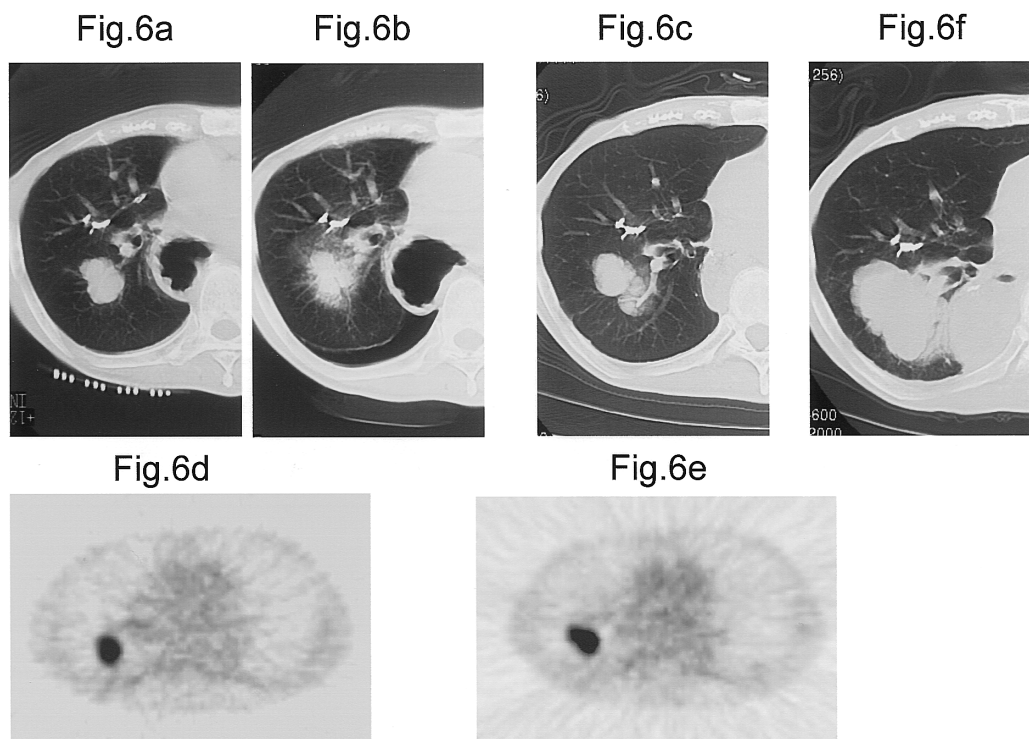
Transverse CT and PET images obtained in a 71-year-old man (Patient 8b) with a metastatic right lower lobe cancer from the esophagus. (a) Transverse CT image obtained before RFA shows a tumor 30 mm in diameter. (b) CT image immediately after RFA, which shows increased opacity around the lesion. (c) CT obtained 2 months after RFA shows no marked changes in size (considered as stable disease). (d) PET before RFA demonstrates FDG uptake with SUV of 7.0. (e) SUV decreased to 4.5 on FDG-PET at 2 months after RFA. (f) CT at 6 months, however, shows increased tumor size, representing recurrence.
